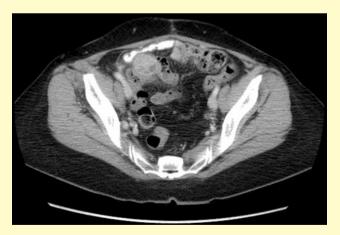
CT scan showing heterogeneously enhancing mass in the right hemipelvis, adjacent to the small bowel and suspicious for recurrence.
